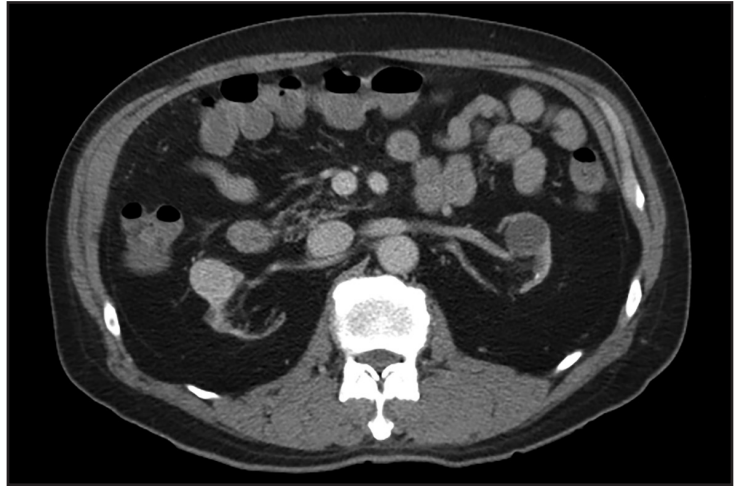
Acquired cystic disease-associated RCC in a 64-year-old man. Axial contrast-enhanced CT image demonstrates bilateral atrophic kidneys with few cysts consistent with acquired cystic kidney disease and a well-circumscribed enhancing mass in the right kidney, which was proven to be renal cell carcinoma on pathologic examination.
